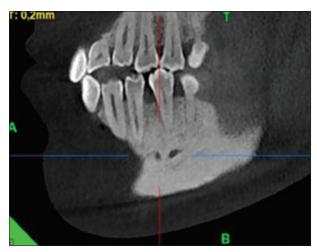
Cone-beam computed tomography image of sagittal section of MF
